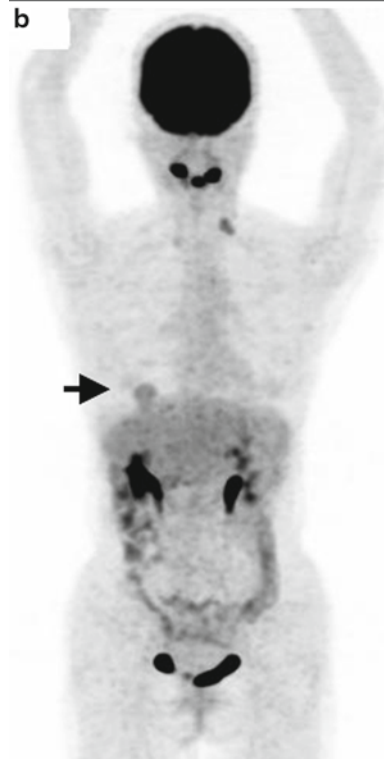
55-y-old woman with liver metastasis of colon cancer. Lesion at dome of liver (*arrow*) is mislocalized to right lung base (*arrowhead*) because of respiratory mismatch on PET images with CT attenuation correction
